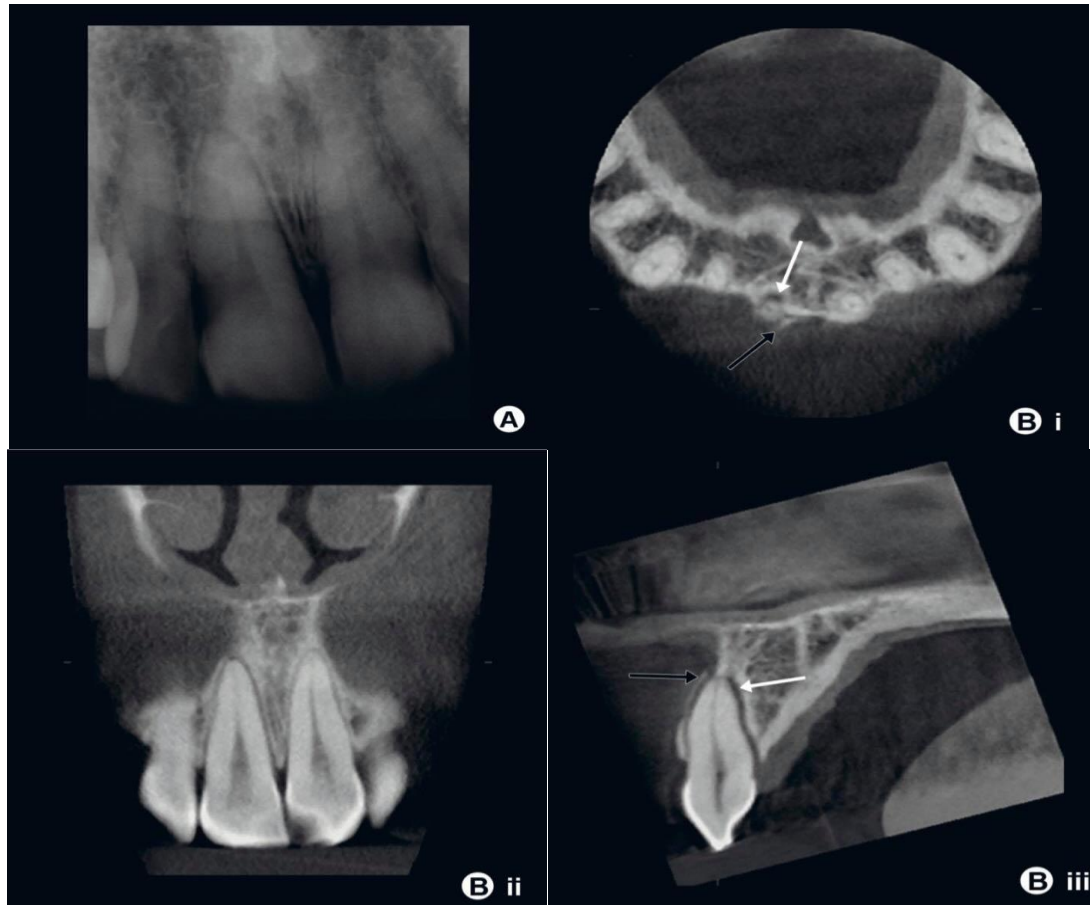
(a) Periapical radiograph of a luxated maxillary right central incisor tooth, following a traumatic dental injury. The radiograph reveals little about the nature and extent of the injury. (b) Axial (i), coronal (ii) and sagittal (iii) CBCT slices through the injured tooth. The crown of the tooth has been luxated palatally resulting in the labial displacement of the root of the tooth through the buccal cortical plate (black arrows). This has resulted in a widening of the periodontal ligament space on the palatal aspect of the root (white arrows).
